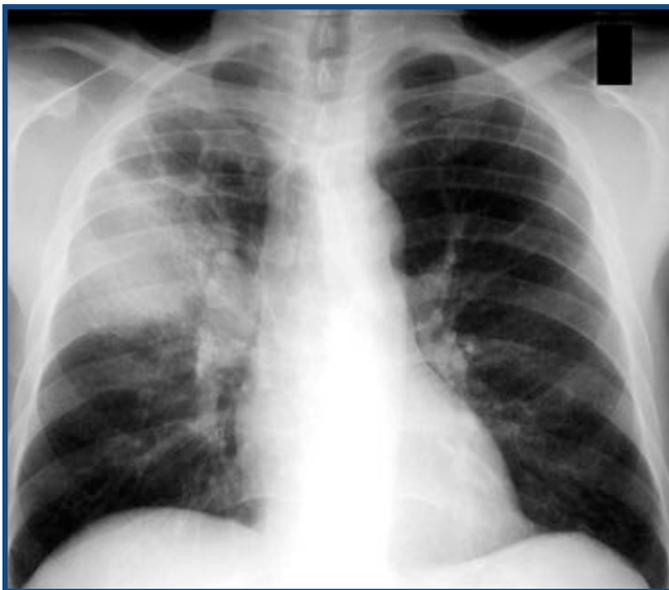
Chest radiograph showing community acquired pneumonia involving the right upper lobe.
